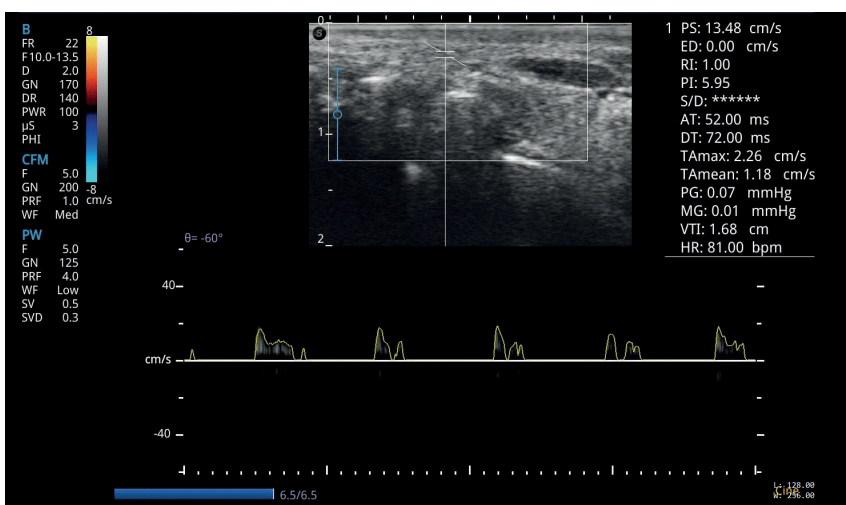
Doppler of the patient O. subgroup G. 1.2 of the main group, in 6 months after the beginning of treatment
